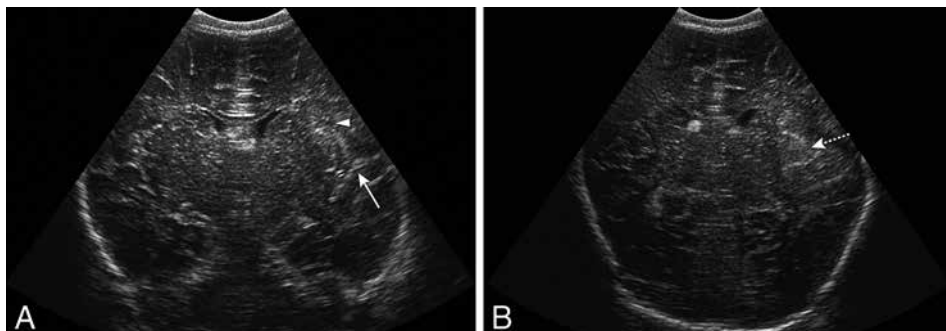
Coronal ultrasound scans in full-term neonate presenting with convulsions, showing asymmetry of the Sylvian fissures (arrow) and subtle increased echogenicity in the parenchyma on the left side (arrowhead) in (A), and area of increased echogenicity in the left parietal lobe (dotted arrow) in (B). The increased echogenicity represents infarction in the territory of the left middle cerebral artery.
